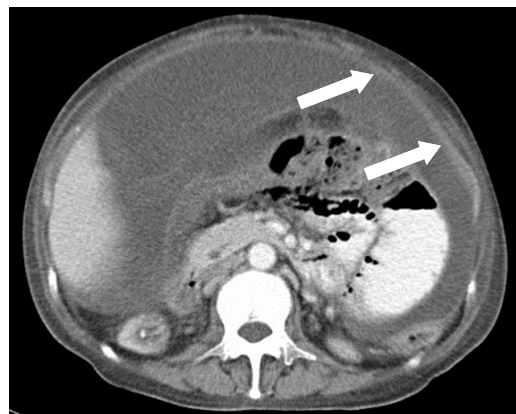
Axial CT abdomen of Case 2 also demonstrating enhancing thickened peritoneum (arrows) with ascites.
